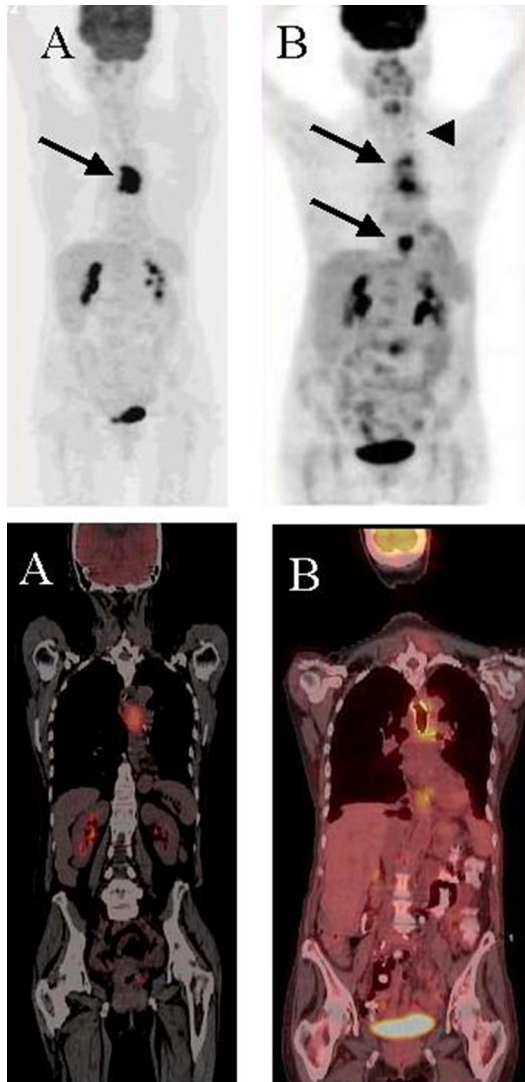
61-year-old woman with well-differentiated adenocarcinoma of mid-thoracic esophagus. PET/CT at baseline (a): marked focal uptake of FDG identified in mid-esophageal tumor (arrow). Follow-up PET/CT (b) showing progressive disease: more extensive tumor infiltration along the esophagus (arrows), and new uptake in a small left supraclavicular lymph node (arrowhead)
